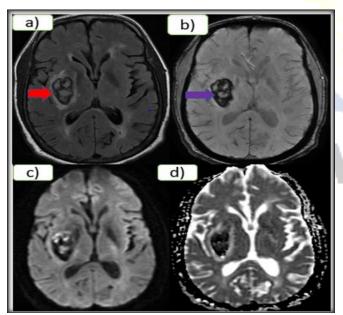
(a-d) showing Acute Intraparenchymal hemorrhage in the region of the right capsulo-ganglionic region with adjacent vasogenic edema. a)There is a well-defined heterogenous FLAIR hyperintense lesion (red arrow) noted in capsule-ganglionic region. Fig b) showing blooming (purple arrow) on SWAN in the affected region. Fig c &d- the lesion is not showing any true diffusion restriction
